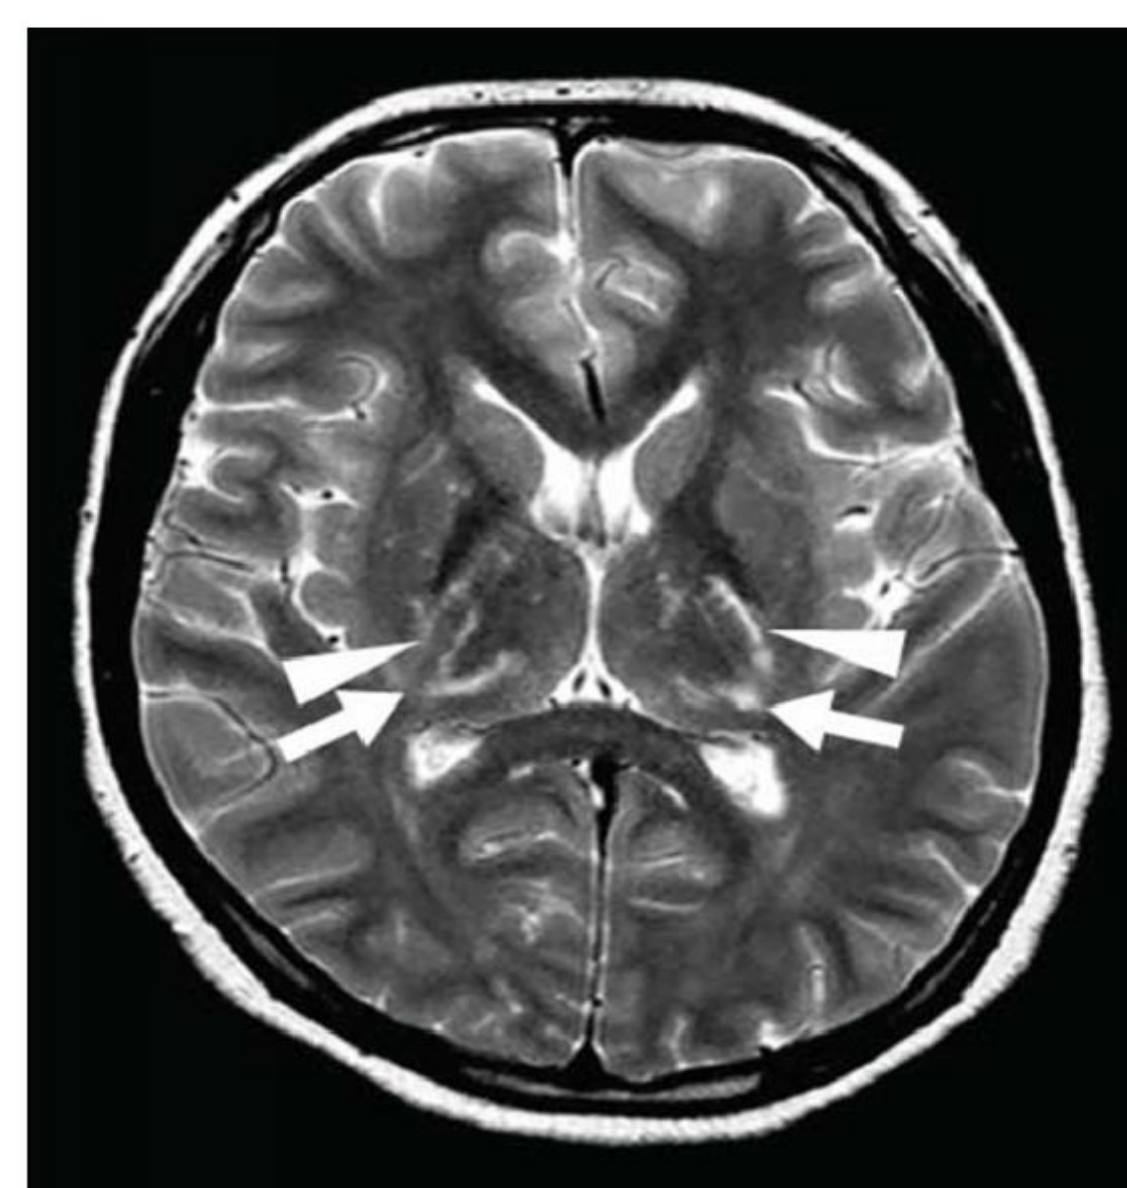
Example of a comparative MRI brain scan displaying thalamic changes. <https://www.hindawi.com/journals/bn/2014/154631>
